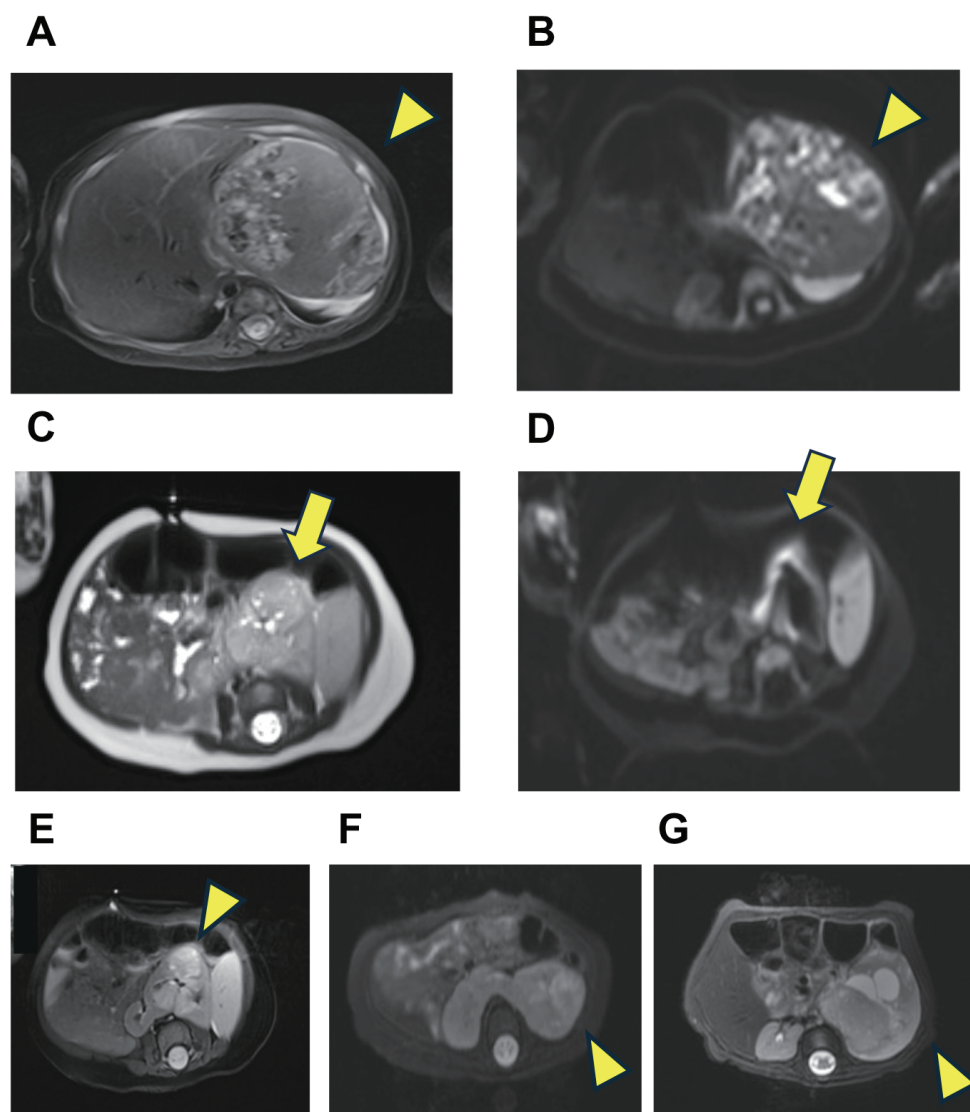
Magnetic resonance imaging findings of liver and kidney tumors
